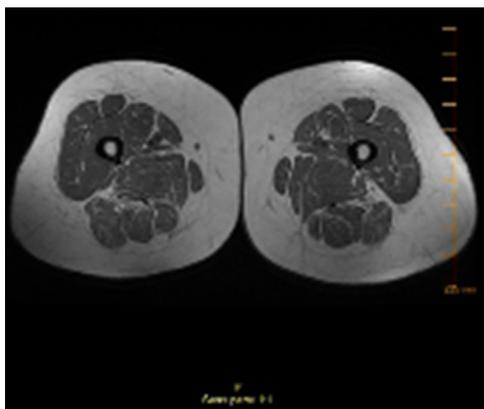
Fat involution in muscles and a mild STIR signal on the right vastus medialis on MRI.
